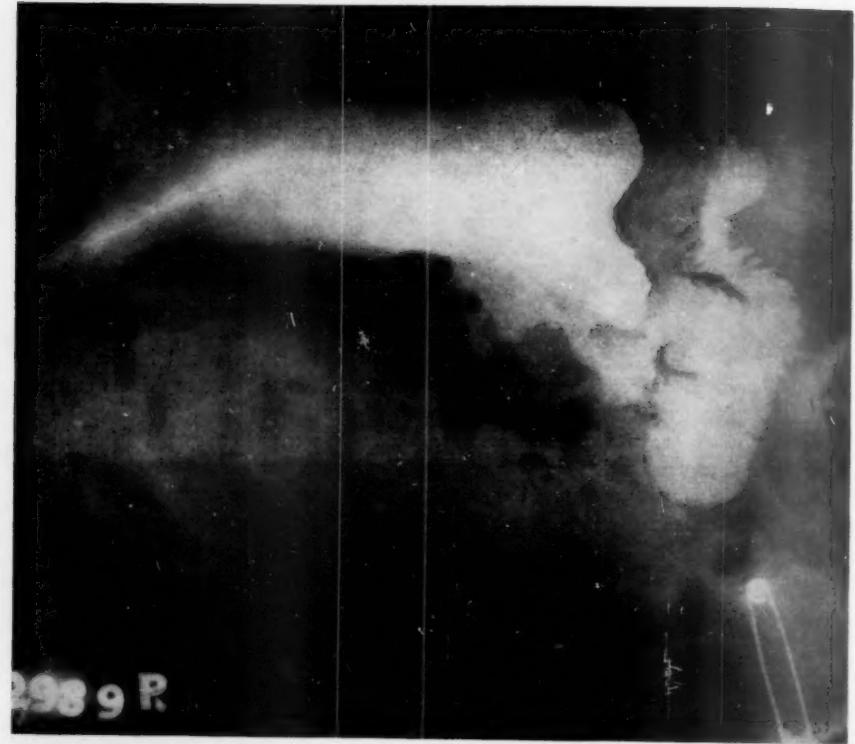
April 16, 1931. Radiograph showing defect in pyloric part corresponding to annular ulcer.
